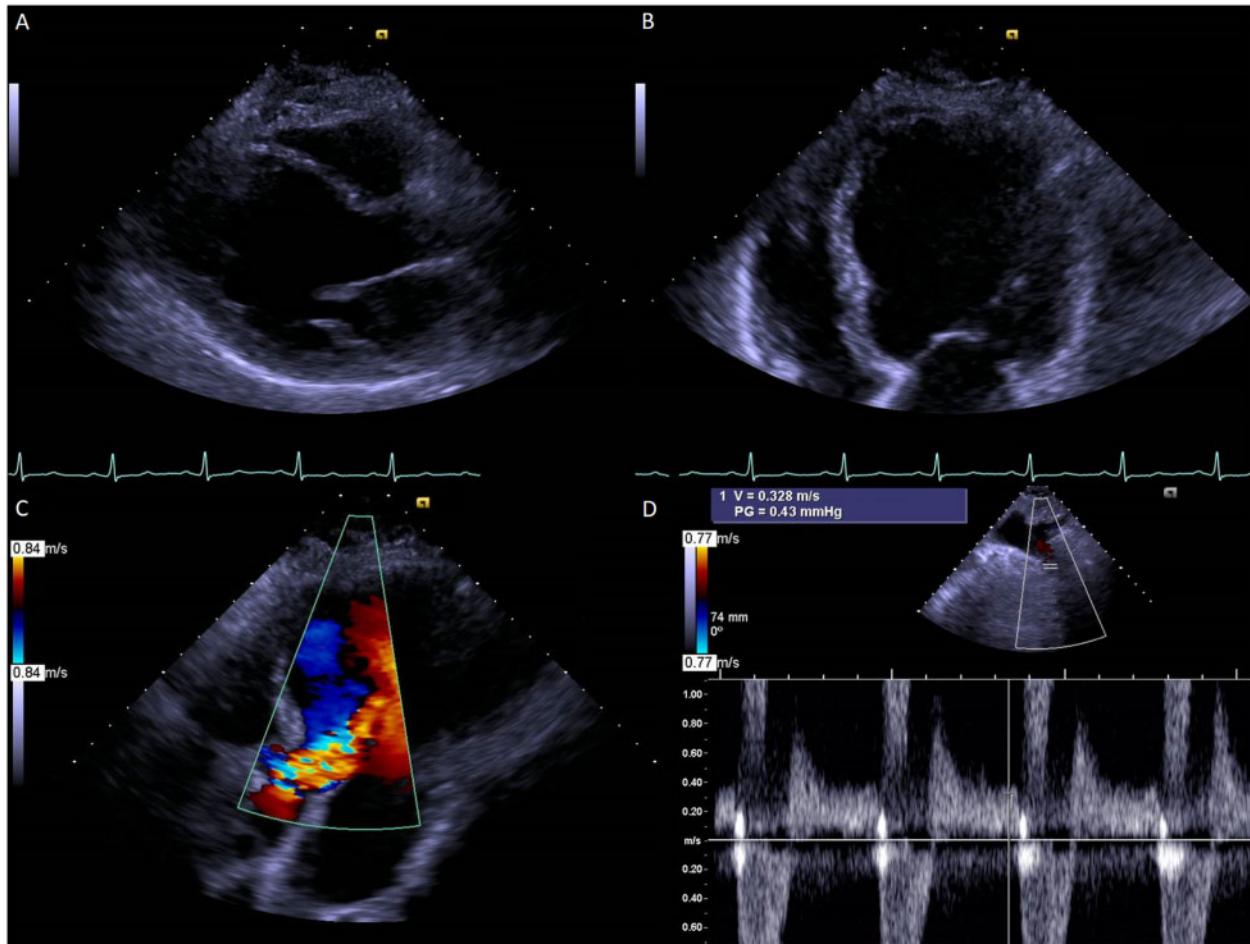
Transthoracic echocardiography showed a severe aortic regurgitation in a severely dilated left ventricle (indexed left ventricular end-diastolic volume 94 mL/m^2 , normal value $29\text{--}61 \text{ mL/m}^2$) and a mildly depressed systolic function (left ventricular ejection fraction 45%, normal value 54–74%). (A) Parasternal long-axis view showing the severely dilated left ventricle. (B) In the apical four-chamber view, the spherical form of the adversely remodelled left ventricle was appreciated. (C) The apical five-chamber colour-Doppler view displaying a severe aortic regurgitant jet. (D) Suprasternal view showing a holodiastolic backflow in the descending aorta with an end-diastolic velocity of 33 cm/s.
